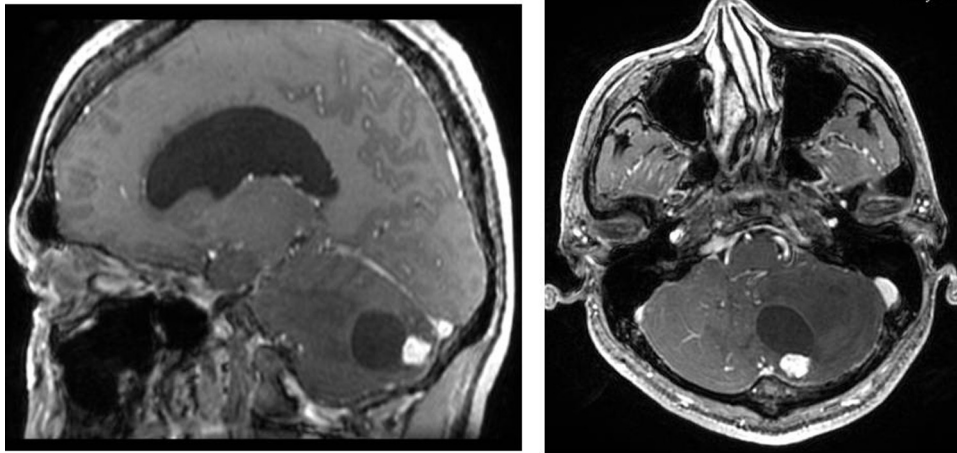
Axial (left) and sagittal (right) T1-weighted magnetic resonance images with gadolinium demonstrating a left cerebellar hemangioblastoma with a mural node causing obstructive hydrocephalus.
